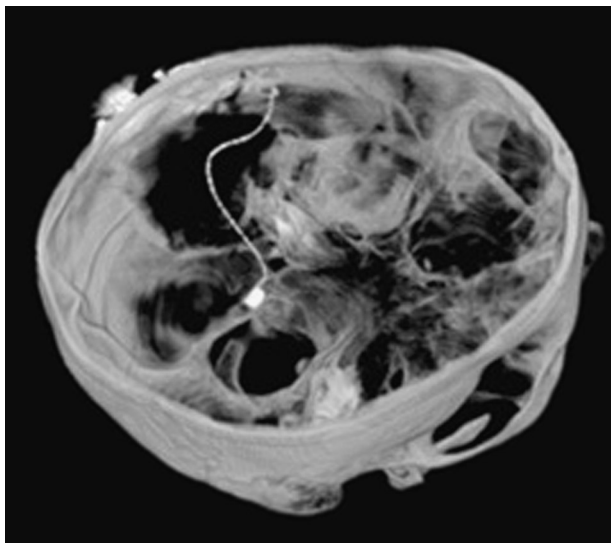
Three-dimensional computed tomographic scan of the postoperative result after placement of a right-side ABI.
